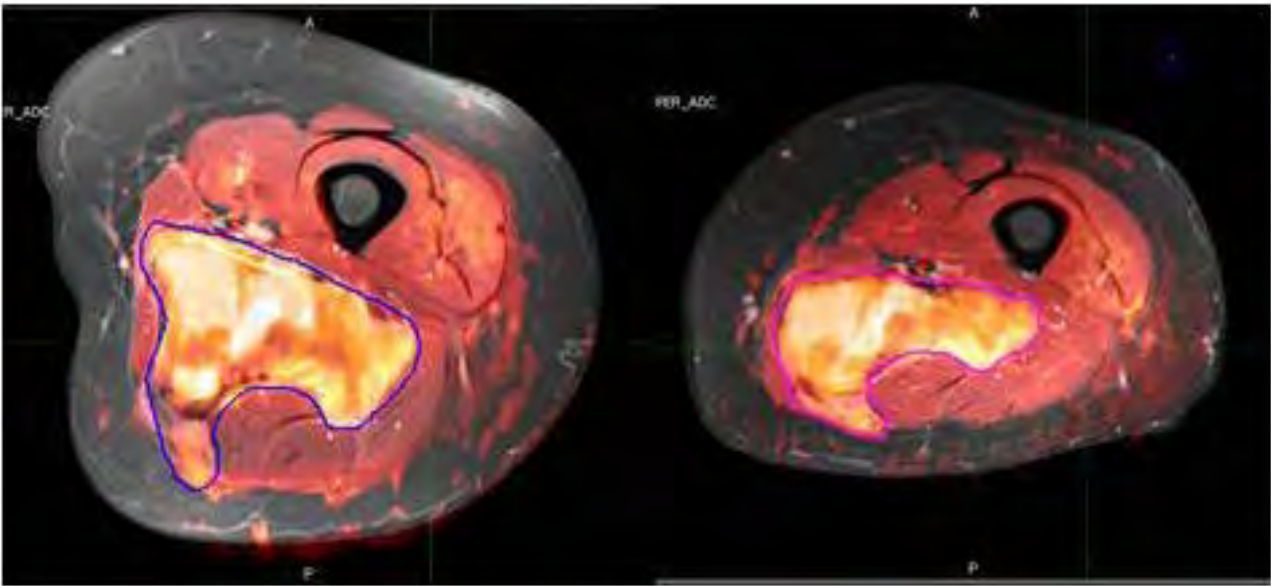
Fusion of DWI and T1 post-contrast MRIs A) Pre-Therapy B) Post-Therapy
